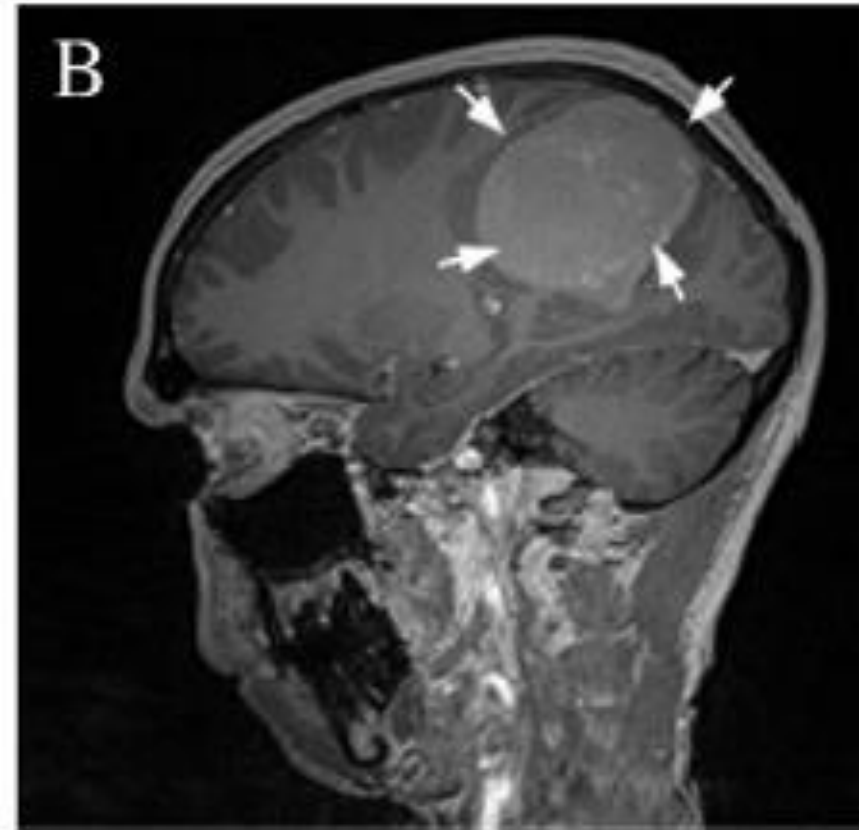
Degree of enhancement of same tumor (meningioma) of different patients on postcontrast T1-weighted images. (A) Full enhancement of meningioma tumor (hyperintense signal). (B) No enhancement of meningioma tumor (isointense signal).
